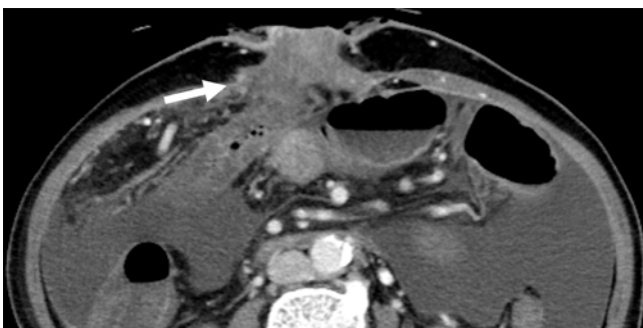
Computed tomography revealing the obliteration of the stomal varices 4 days after the procedure (white arrow).
